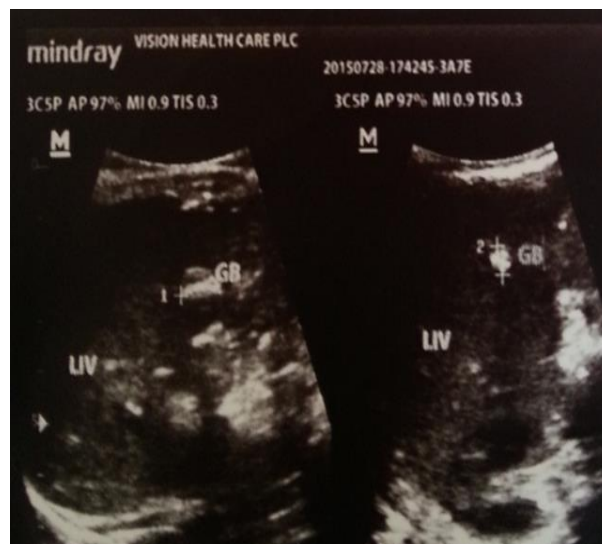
Ultrasound demonstrating gallstones in a 9-month-old female infant
